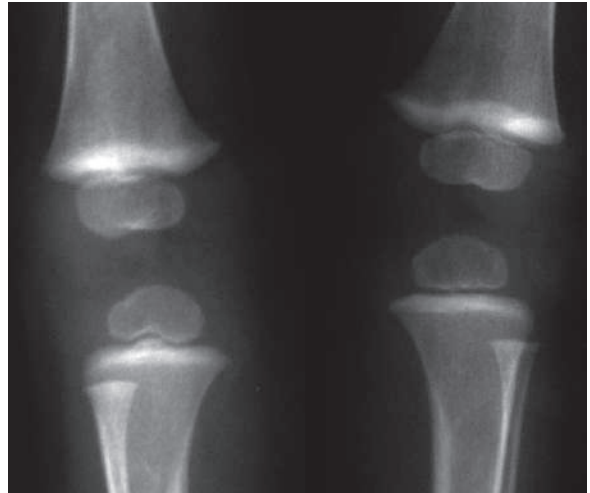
Anteroposterior plain radiograph of both knees in a child with lead poisoning shows dense metaphyseal band sign in the distal femur and the proximal tibia of both knees. The right proximal fibular metaphysis shows also the dense metaphyseal band as a strong indication of lead poisoning
